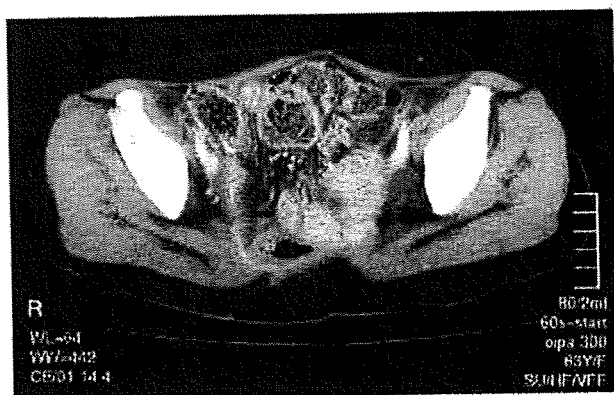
A computed tomogram shows successful coverage of the small intestine with sufficient flap volume.
